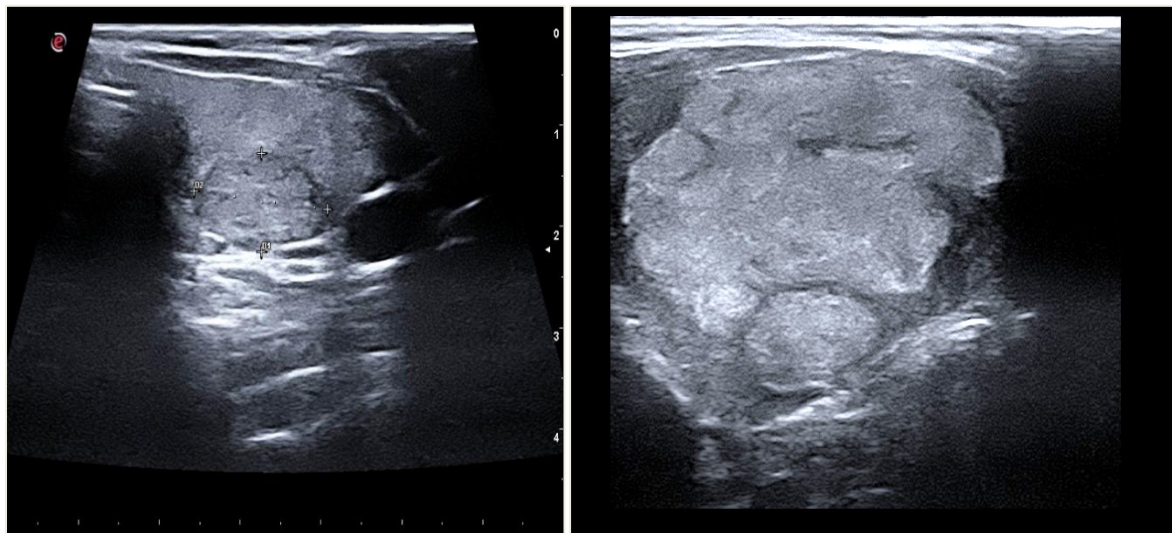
Ultrasonography images of Multinodular goiter
